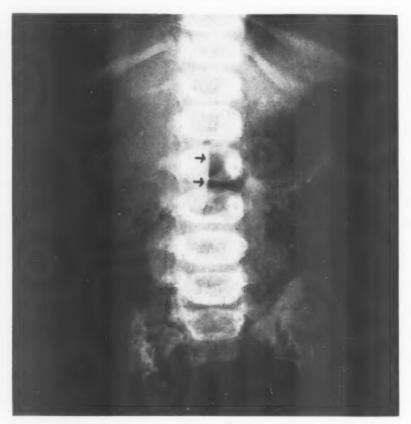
Plain roentgenogram of the abdomen. Arrows show air-filled duodenum deformed by the tumor.
